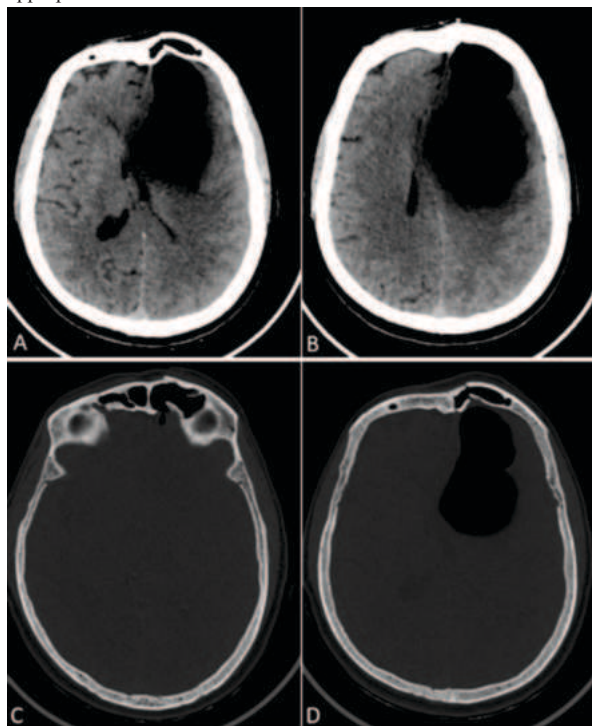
CT Brain Parenchyma (A,B) Axial view showing Tension intraparenchymal pneumocephalus with perilesional edema noted involving left frontal lobe causing mass effect and midline shift to right with subfalcine herniation; Bone window (C,D) showing defect in posterior wall of left frontal sinus.
